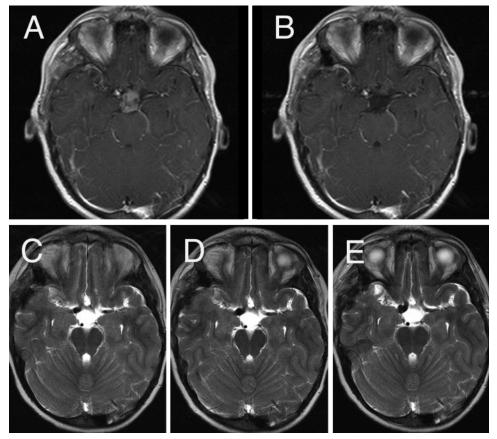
This boy presented with short stature at the age of 10 years and was found to have a 2-cm retrochiasmatic craniopharyngioma (A) that was completely resected (B). On 3.5-month follow-up MR imaging (C), he was noted to have a right FDCA (from a baseline of 4.2 mm to 5 mm). Imaging at 9 months (D) showed further increase in size; 12-month follow-up imaging (E) showed that the lesion had stabilized at 9 mm.
